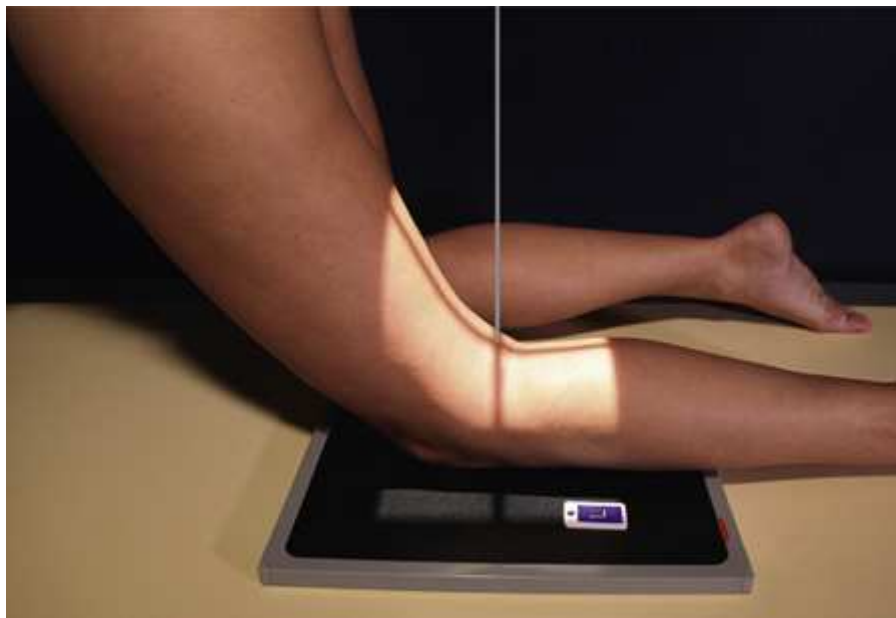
PA axial intercondylar fossa, kneeling on a radiographic table: original Holmblad method.
